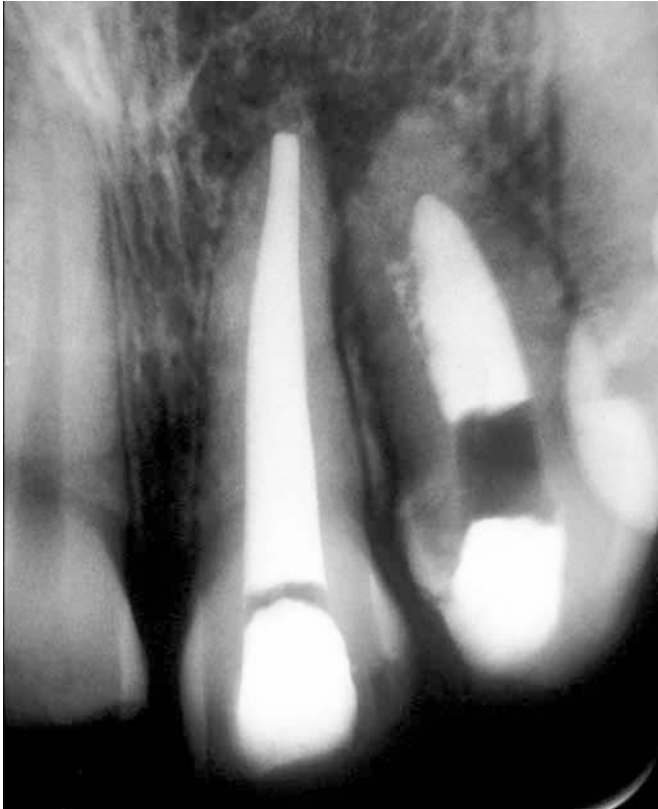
Teeth with intracanal dressing after a period of nine months, showing regression of the periapical lesion, stabilization of the beginning of resorptions and root closure.
